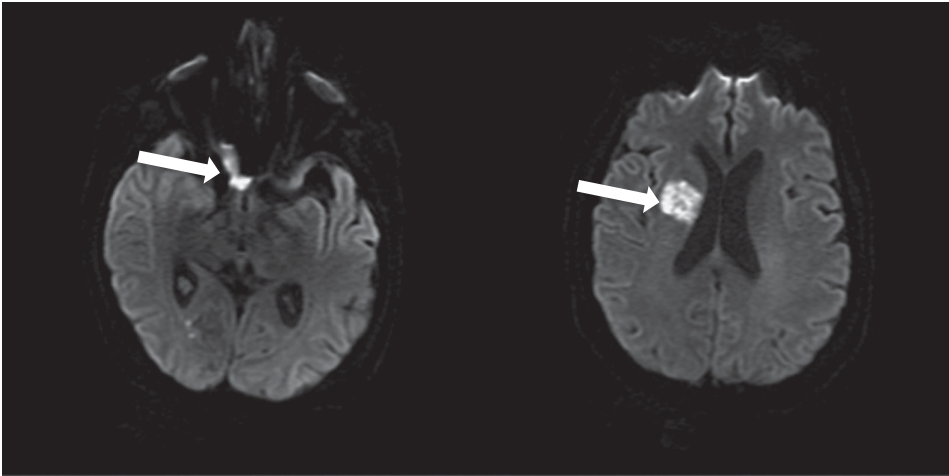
Diffusion-weighted brain MRI images showing involvement of the a) right optic nerve and chiasm, and b) right basal ganglia.
